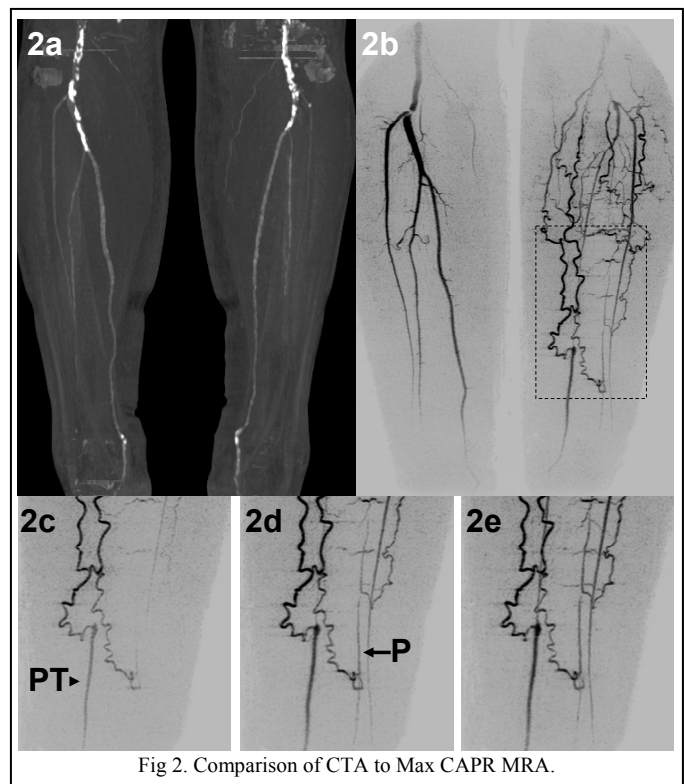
Comparison of CTA to Max CAPR MRA.
